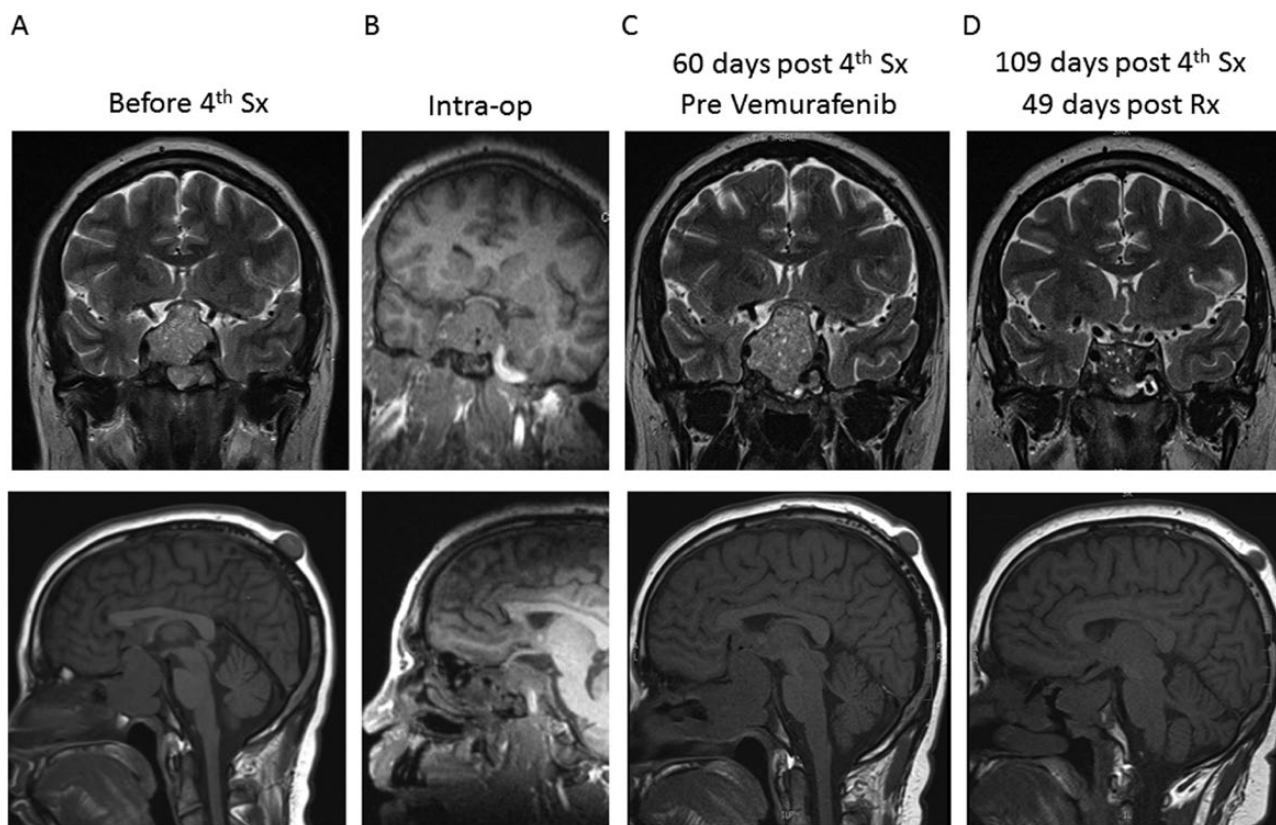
MRI scans around the time of his 4th transsphenoidal surgery and after treatment with vemurafenib. A: MRI scans before surgery that demonstrated a 3.4-cm enhancing mass in the sella with extension into the suprasellar cistern causing elevation of the optic chiasm. B: Intraoperative MRI that showed partial resection of the tumor. C: MRI scans 60 days after the 4th transsphenoidal surgery that showed rapid tumor regrowth. D: MRI scans that showed a 55% reduction in tumor size 49 days after treatment with vemurafenib. Abbreviations: Intra-op, Intraoperative MRI; MRI, Magnetic resonance imaging; Rx, treatment with vemurafenib; Sx, surgery.
